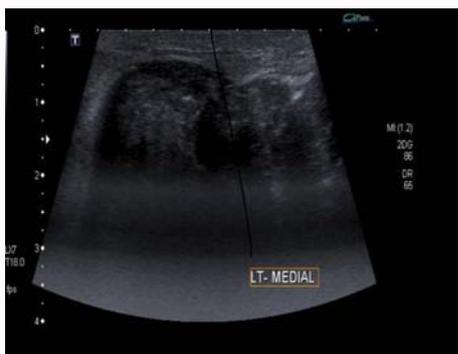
Ultrasound was reported an avascular heterogeneous hypochoic mass occupying most the left breast.
